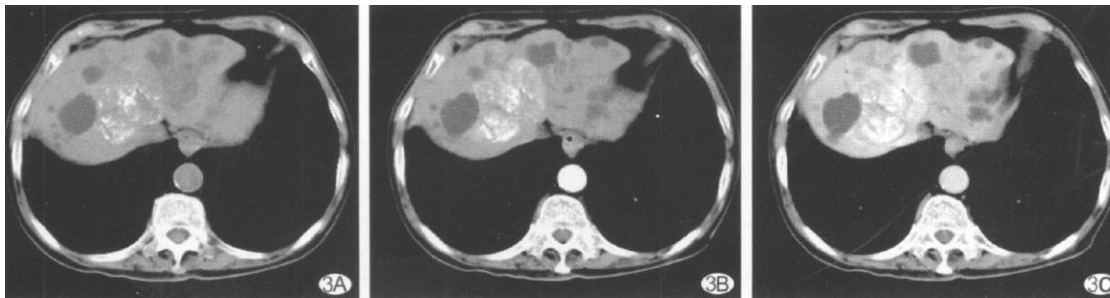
Double blood type A:. CT scan of the iodized oil and the surrounding area of low density tumor. B:The tumor survival area was significantly enhanced in the arterial stage (CT was 98Hu); C: portal intravenous liver parenchyma, and increased tumor survival area (112 Hu).
